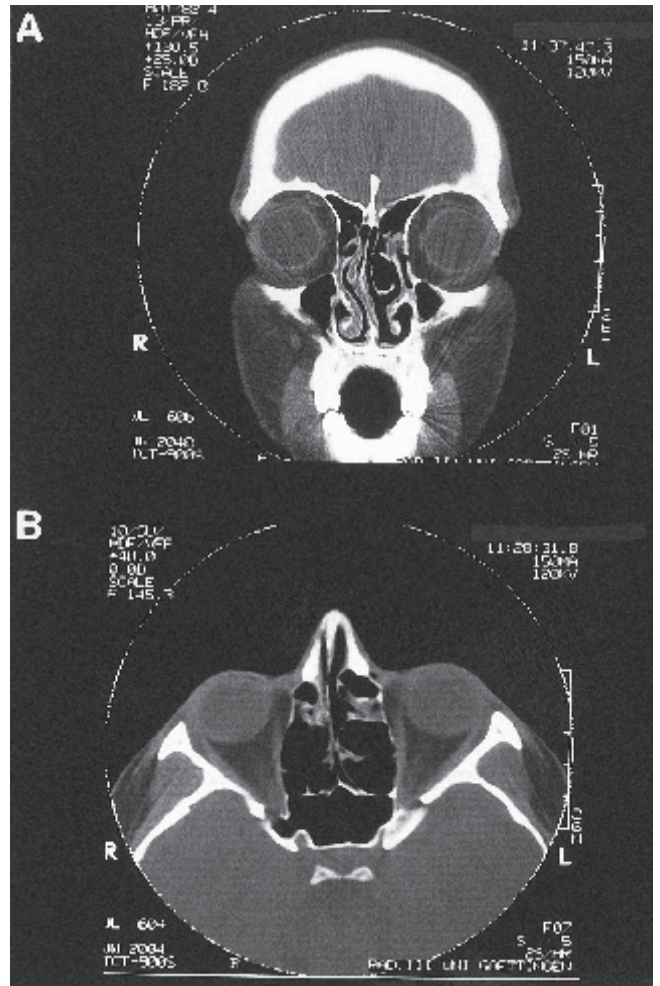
Pre-operative paranasal sinus CT scans (November 5, 1996): coronal (A) and axial (B) sections. Circumscribed opacity is found only in single anterior ethmoidal cells. Upon surgery (November 6, 1996), however, nearly all ethmoidal cells appeared to be filled with polypous mucosa. The sphenoid sinuses on both sides seem to be free, with relatively extended pneumatization. The right optic nerve seems to run partially free through the sphenoid sinus (B).
